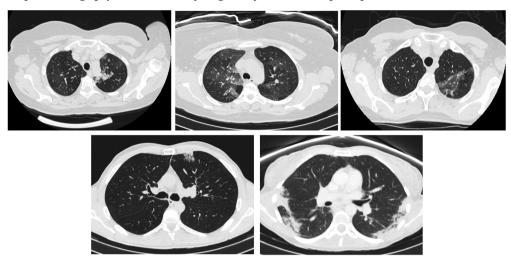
Chest computed tomography at the moment of diagnosis of chronic eosinophilic pneumonia.
